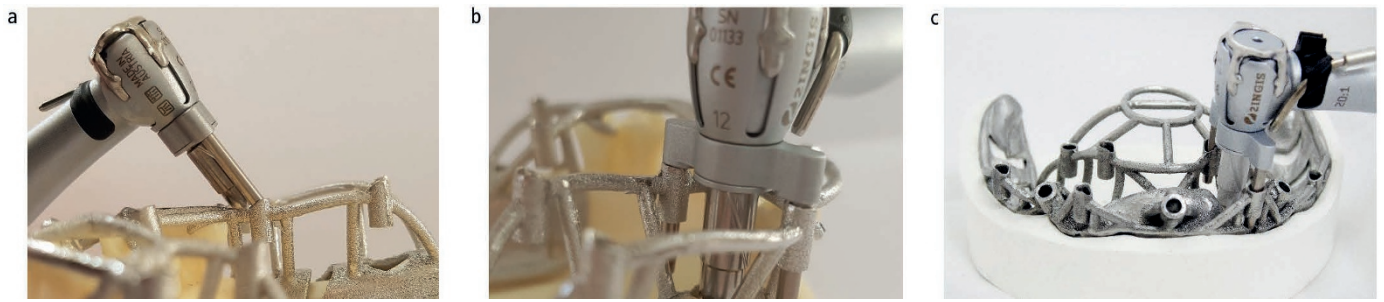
Shows a ImplantPilot system surgical stent constructed from cobalt chromium which utilises bilateral tubes to guide the preparation of the implant bed/implant placement to minimise deviation from the planned CBCT implant position
